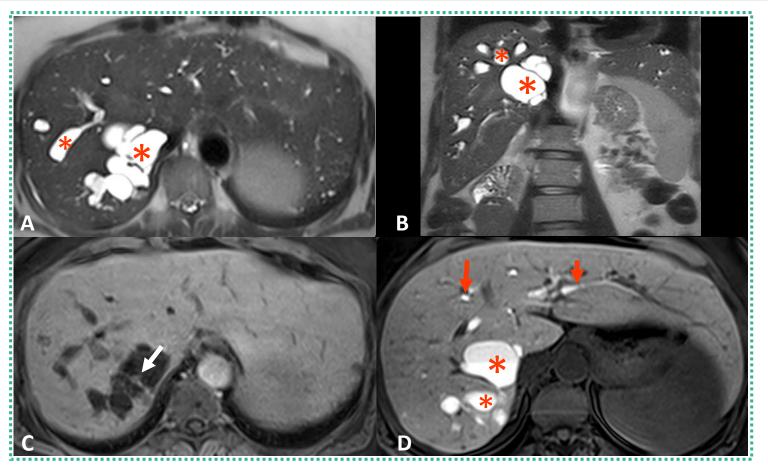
Contrast-enhanced MRI (with hepatobiliary contrast) – Caroli disease.
